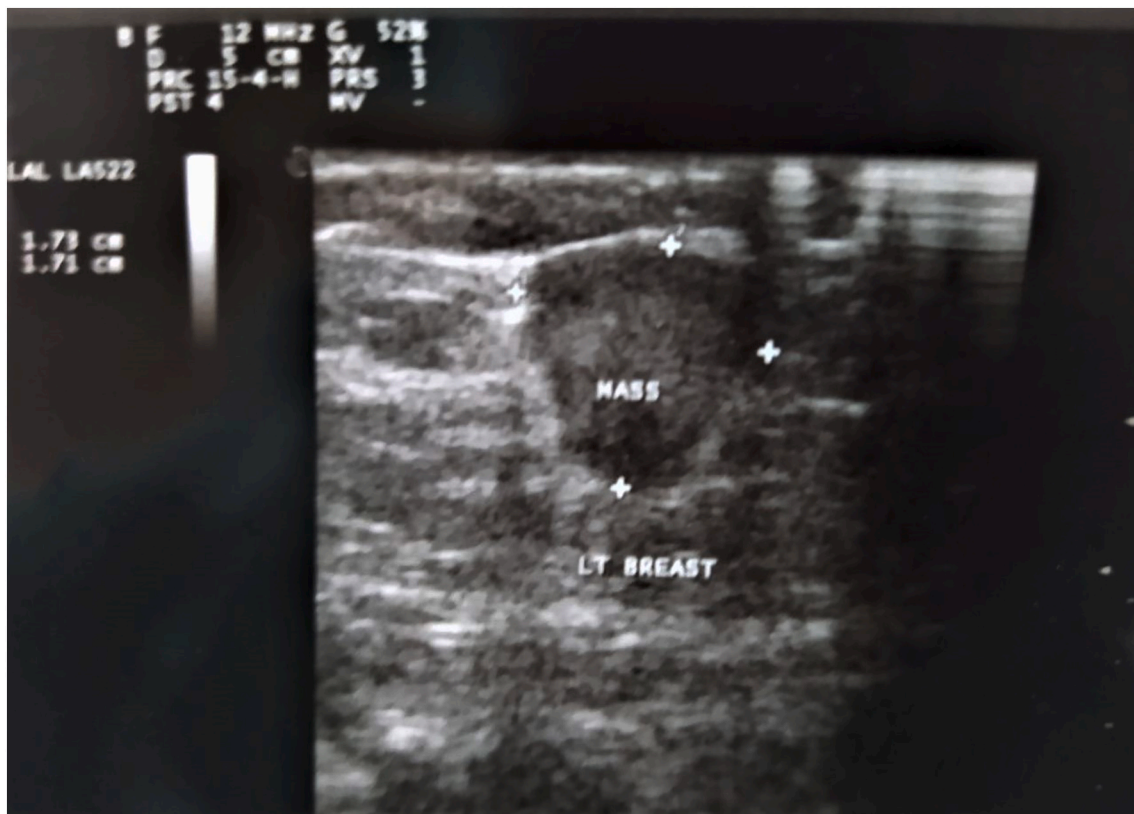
Diagnostic breast Ultrasound revealed within the left breast, a hypoechoic retro-auricular mass was noted. Its borders were ill-defined and positioned at the 6 o'clock spot. The lesion measured approximately (1.73 × 1.71 cm).
